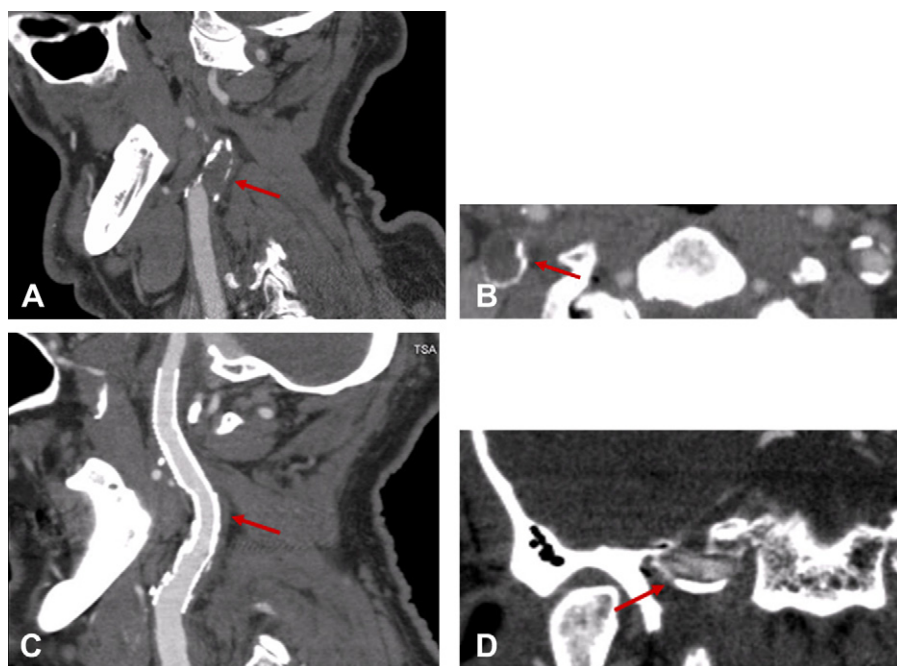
CTA. A Lateral projections: right carotid artery occlusion (arrow) at the carotid bifurcation before the intervention. B Axial projection: "ring sign" (arrow) in right carotid artery. C Lateral projection: complete
